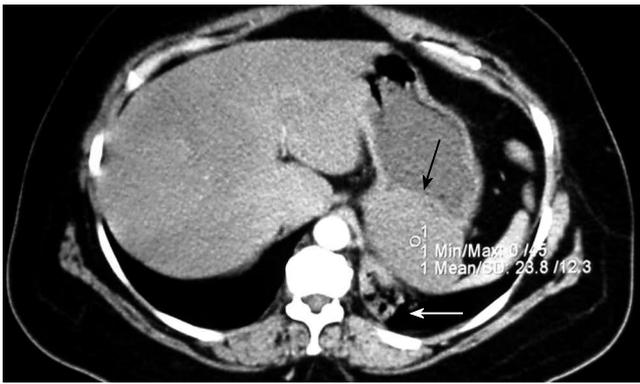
Abdominal CT scan demonstrating a cystic lesion attached to the posterior gastric wall (black arrow) and a pulmonary sequestration in the left pulmonary base (white arrow).
